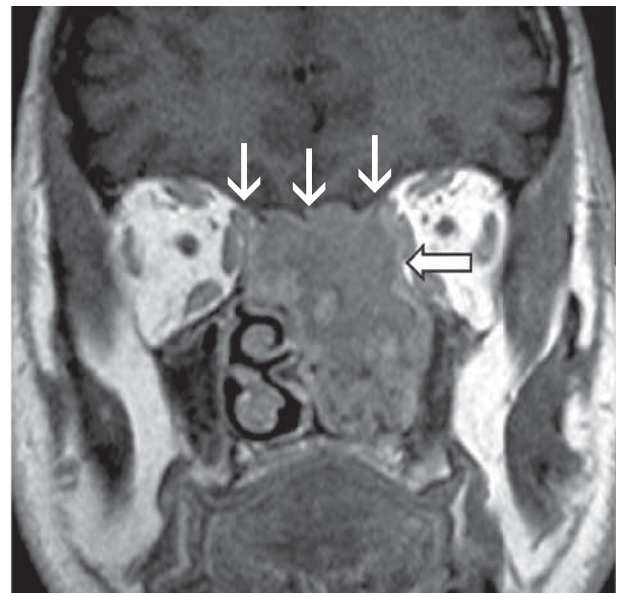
Coronal contrast-enhanced T1-weighted image shows squamous cell carcinoma of ethmoid cells. Inhomogeneous tumor mass without intracranial extension is seen (white arrows). Intraorbital tumor propagation pressing medial orbicular muscle is shown (empty white arrow).
